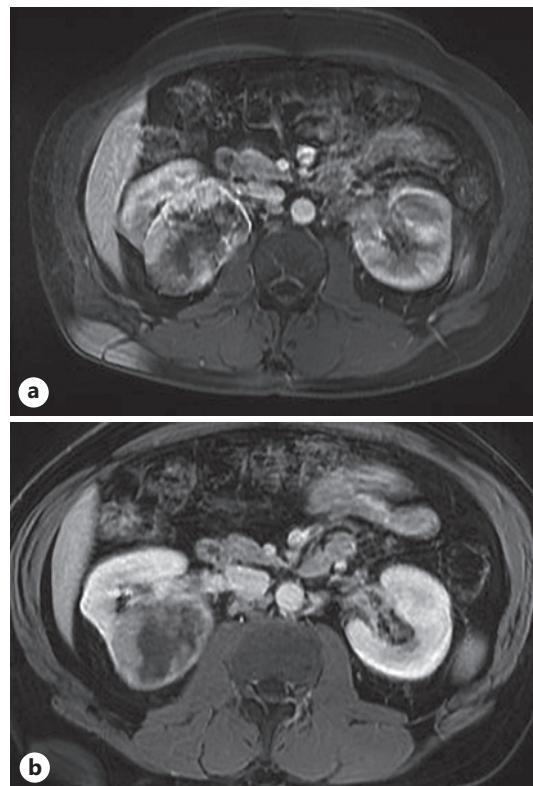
a Contrast MRI of kidneys prior to treatment. Initial MRI demonstrated a heterogeneously enhancing large right renal mass ($10.4 \times 7.8 \times 6.1$ cm) and hypoenhancement of the inferior aspect of LT kidney with enhancement of LT renal vein. b Contrast MRI post-neoadjuvant immunotherapy. Repeat MRI demonstrated interval decrease in size of the right renal mass ($7.0 \times 6.2 \times 8.2$ cm) but unchanged size of the left renal mass with persistent thrombus in left renal vein.
